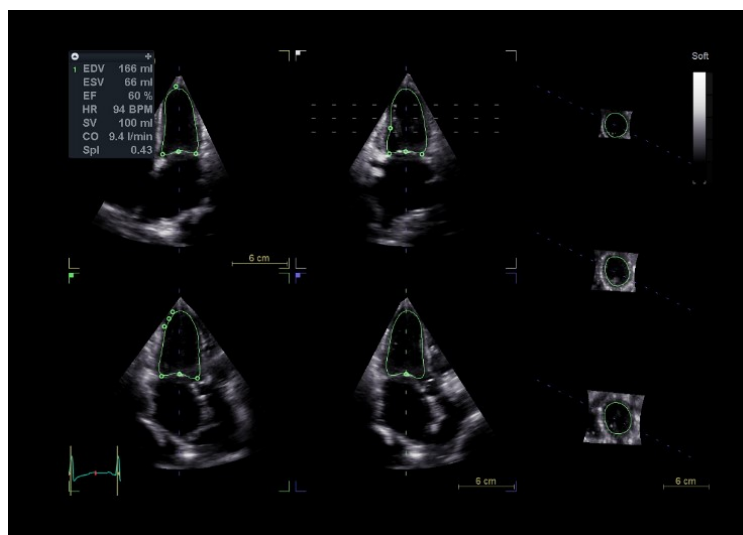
3D Echocardiography.
